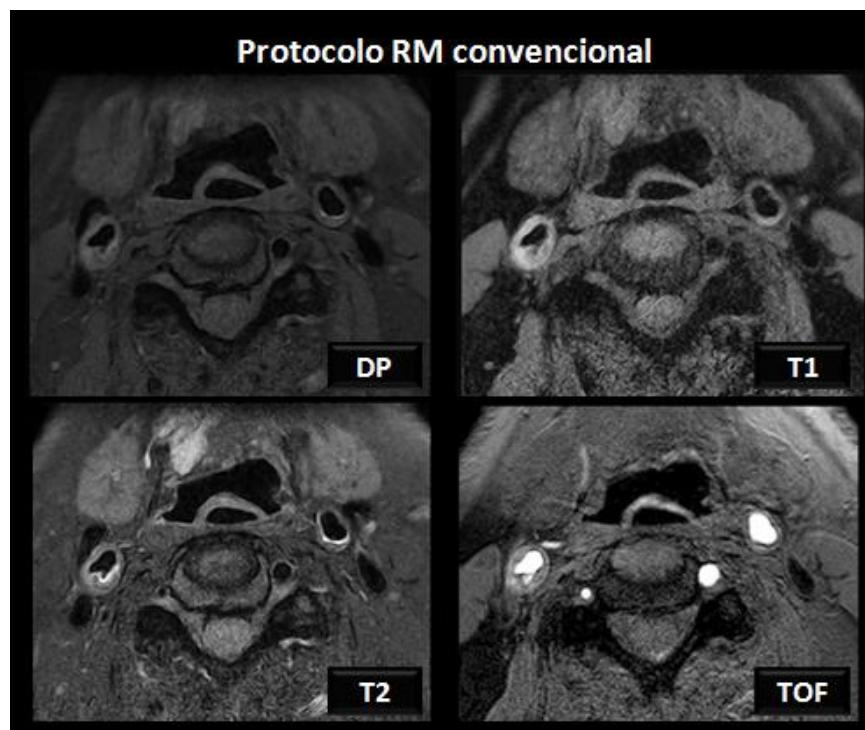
MR image sequences of carotid artery study. Image obtained from the Department of Radiology-IDI of the HDJT.
